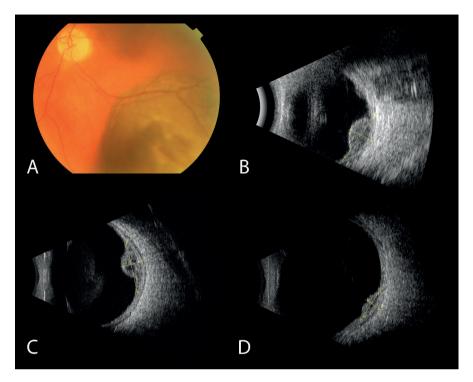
A 66-year-old woman with an uveal melanoma was treated with fractionated stereotactic radiotherapy. At presentation, a T2 tumour is visible temporal inferior of the macula of the right eye (A) and with a tumour thickness of 5.7 mm and a largest basal diameter of 12.1 mm on ultrasound (B). After treatment, ultrasound images showed tumour regression: with a thickness of 4.4 mm after one year (C) and a thickness of 2.7 mm after two years (D). Yellow lines show the points of the tumour measurements.
